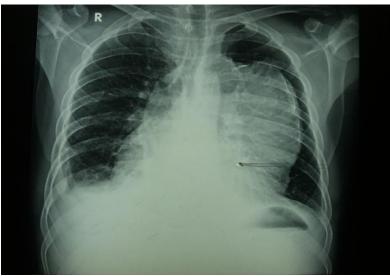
Chest X-Ray showing anterior thoracic mass.
